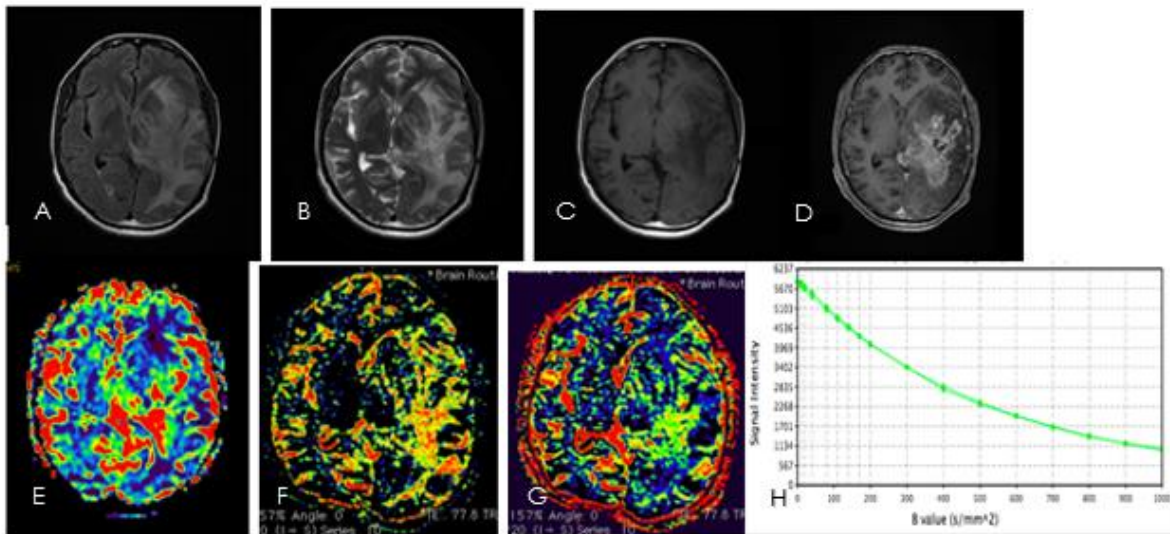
A-C: T2 FLAIR,T2WI,TIWI ,D: Post contrast BRAVO, E :RCBV Map of DSC Perfusion,F-G : D* and f Map of IVIM Imaging,H : Logarithmic plot of signal intensity decay as function of b
